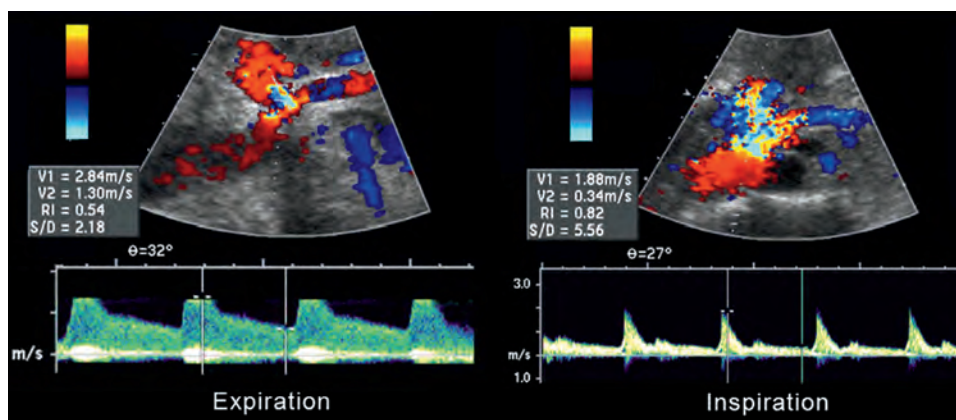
Longitudinal image of the abdominal aorta and celiac artery. The Doppler spectral waveforms were recorded at both phases of respiration. Extrinsic compression of the celiac artery during expiration is a frequent finding. In this example, it causes peak systolic velocities and end-diastolic velocities to increase ($>284/130$ cm/sec) with aliasing noted. During inspiration, velocities decrease to 188/34 cm/sec. Courtesy of Steve Bernhardt, BS, RDMS, RVT, RPhS.
